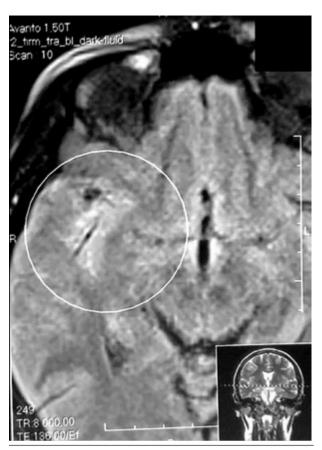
weighted image of MRI brain showing areas of mild increased signal in the right parietal lobe (made soon after admission)
